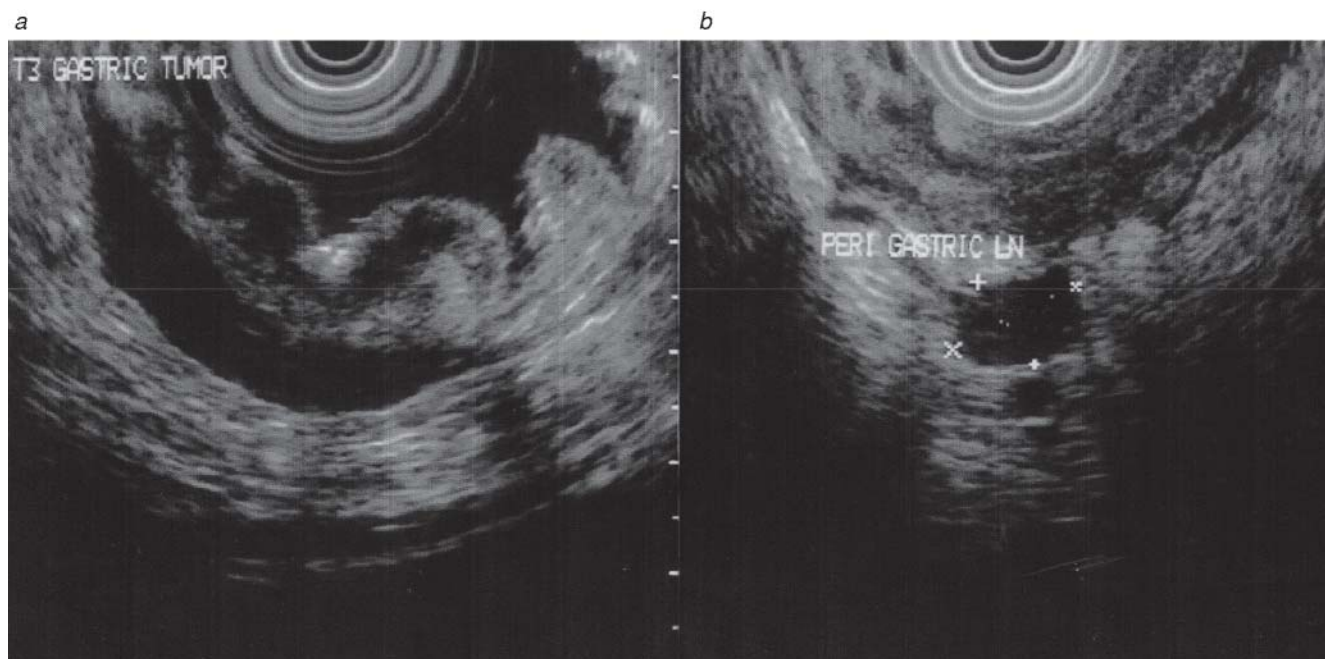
(a) Shown is an endoscopic ultrasonographic (EUS) image of a T3 gastric neoplasm. (b) EUS reveals the presence of suspicious perigastric (N1) nodes, later confirmed as malignant at operation.
